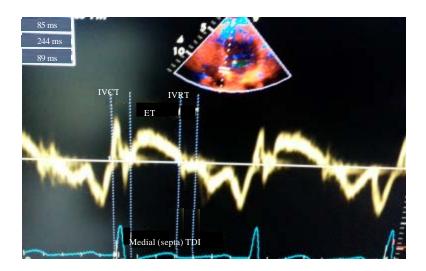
Tissue Doppler imaging of the Medial (septal) mitral annulus with measurement of isovulmic contraction time, Ejection time and isovolumic relaxation time
